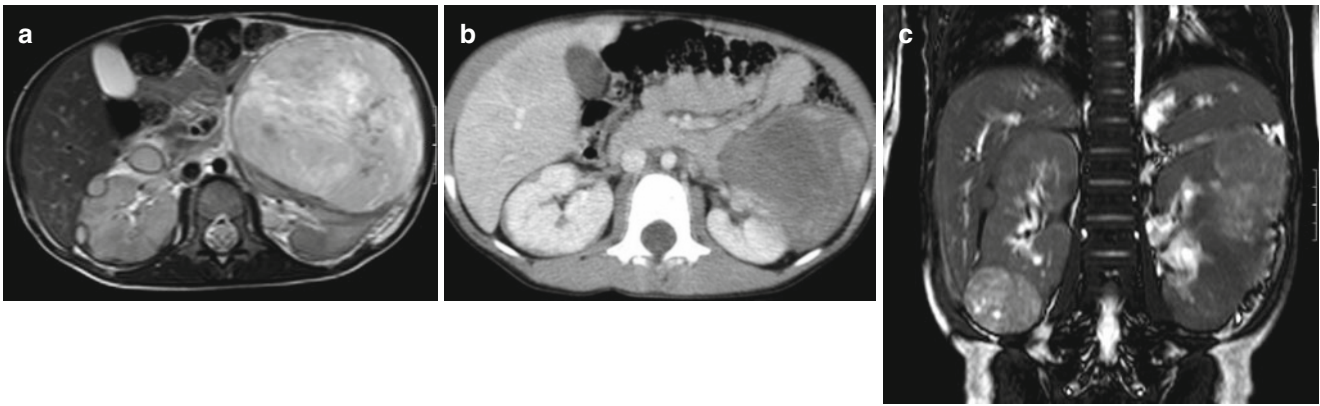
Bilateral Wilms' tumor with nephroblastomatosis. (a) T2 MR sequence showing the large Wilms' tumor in the left kidney and nodules of nephroblastomatosis in the periphery of the right kidney. (b) CT with contrast showing the left-sided Wilms' tumor and additionally both the nodular and plaque-like nephroblastomatosis of the right kidney.
